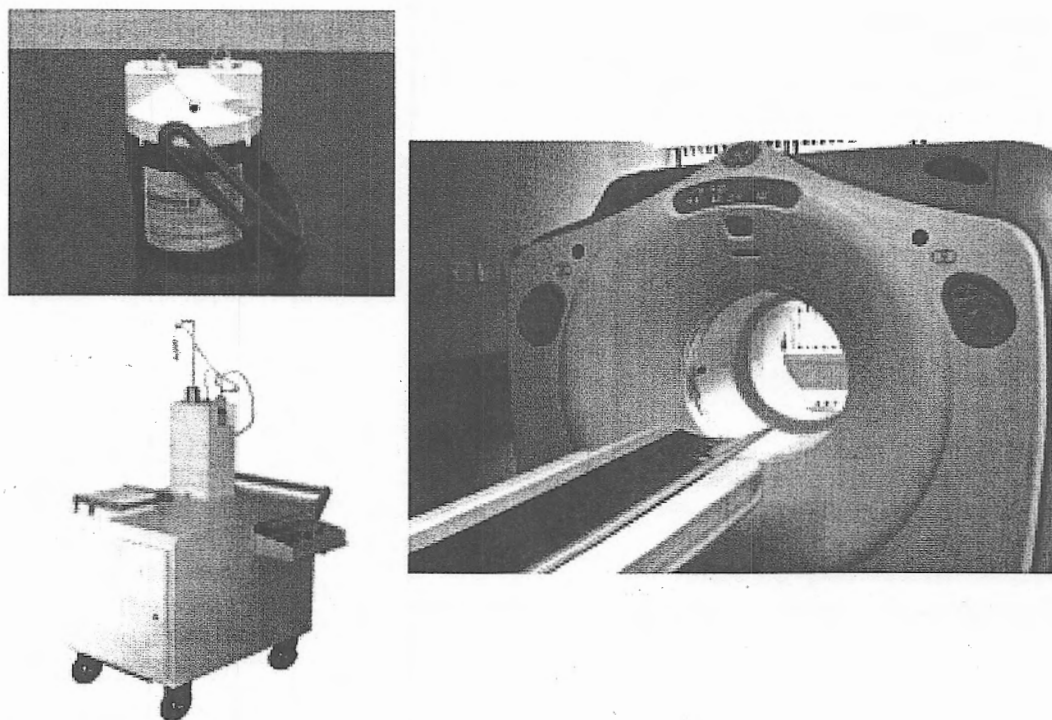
Equipment required for PET perfusion imaging with ^{82}Rb . Clockwise from upper left: ^{82}Rb generator; PET/CT camera; ^{82}Rb generator/storage/infusion cart. Sources of photos: left upper and lower Bracco Diagnostics; right photo author.
